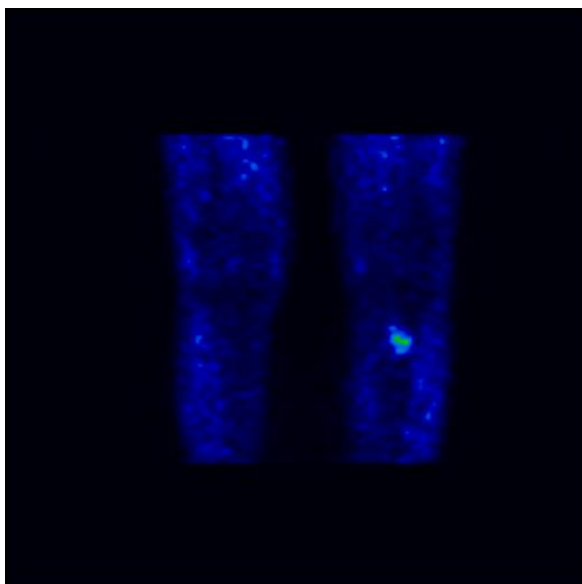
Coronal view of PET (A) of the inferior limb of at knee height. There is a region of increased uptake of ^{11}C -choline in the area of bone thickening evident in the CT scan.
